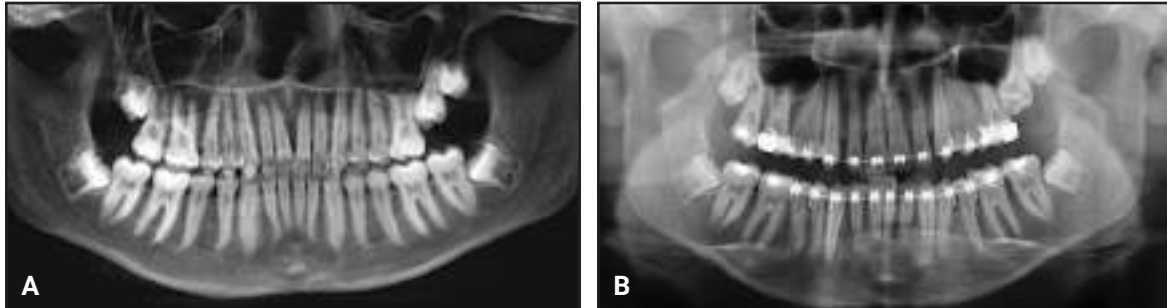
Case 2. A. 14-year-old male Class II, division 1 patient with delayed eruption of upper left second molar before treatment. B. Panoramic radiograph taken eight months after start of treatment shows no change in position of upper left second molar.
